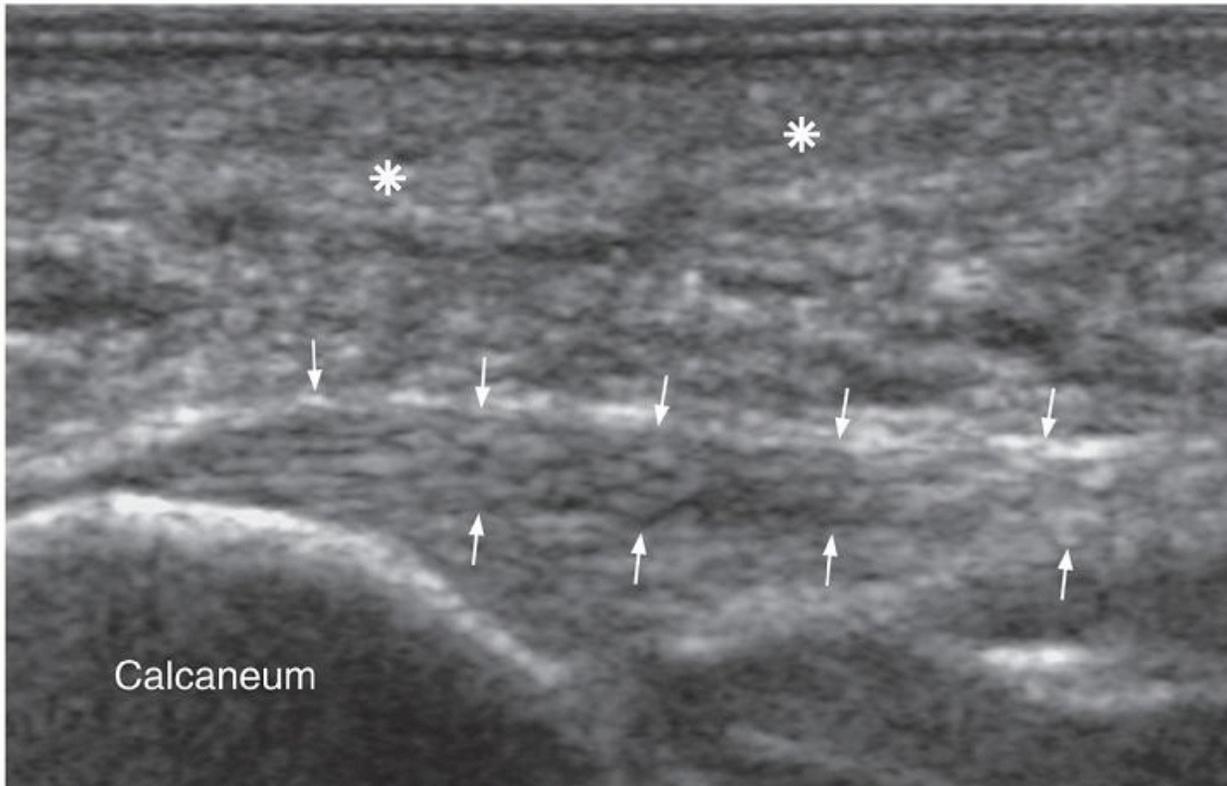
Longitudinal ultrasound showing normal plantar fascia (arrows) attached to the anteroinferior aspect of the calcaneum. As a general guide, the normal plantar fascia is <4 -mm thick at the medial calcaneal tuberosity. Asterisks, heel fat pad.
